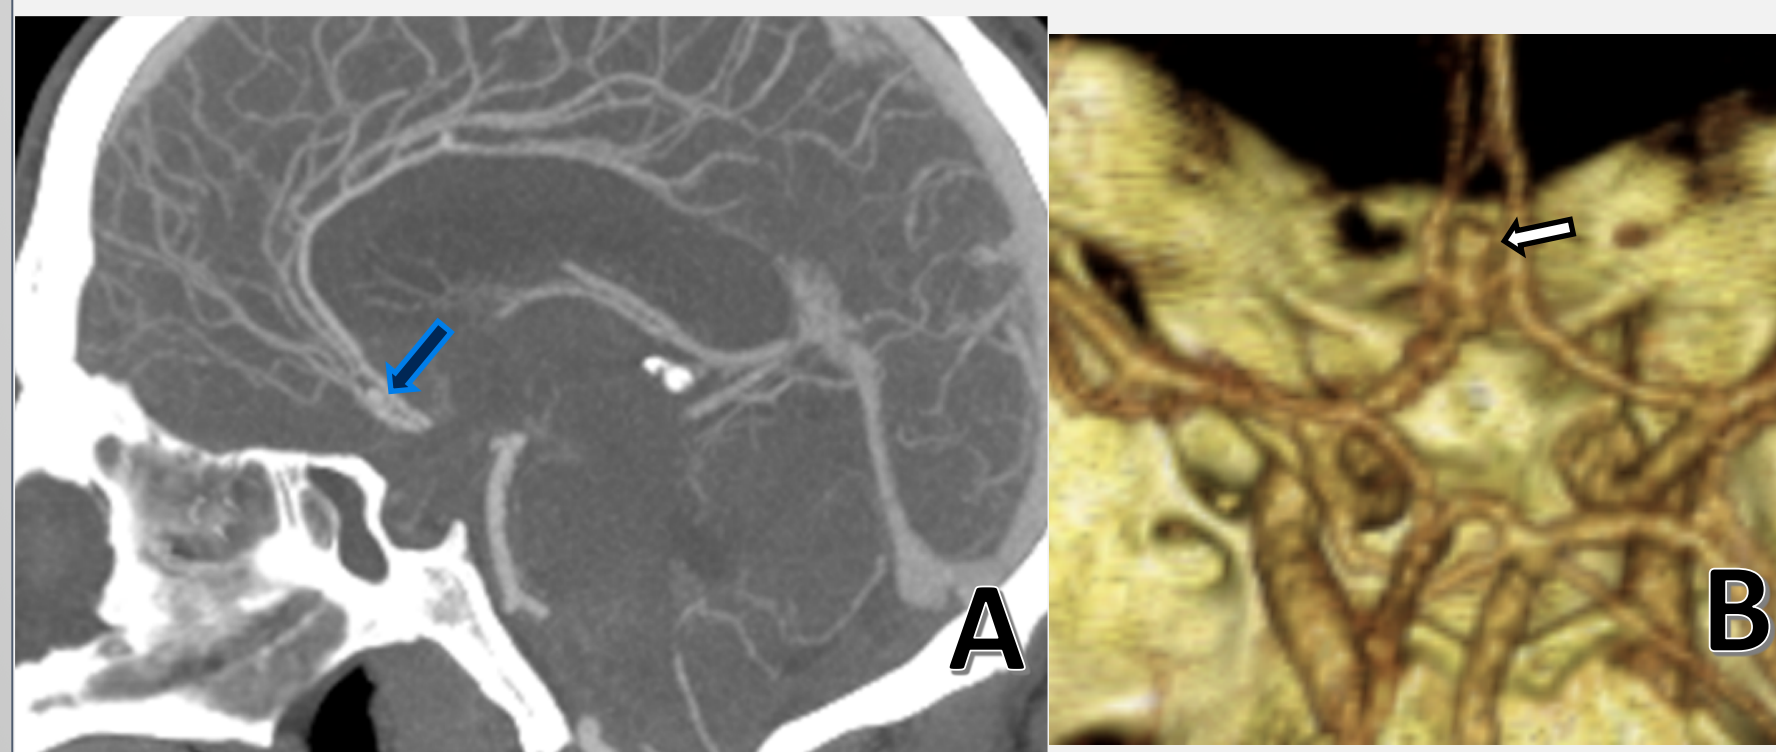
(A) Sagittal CT MIP image demonstrating presence of anterior communicating artery aneurysm (blue arrow) and (B) 3-D reconstruction of anterior communicating artery aneurysm (white arrow).
